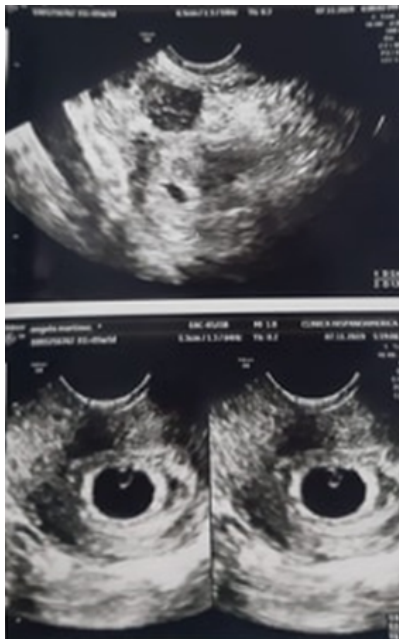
Transvaginal ultrasound with visualization of intrauterine pregnancy less than 6 weeks and right adnexal mass.
